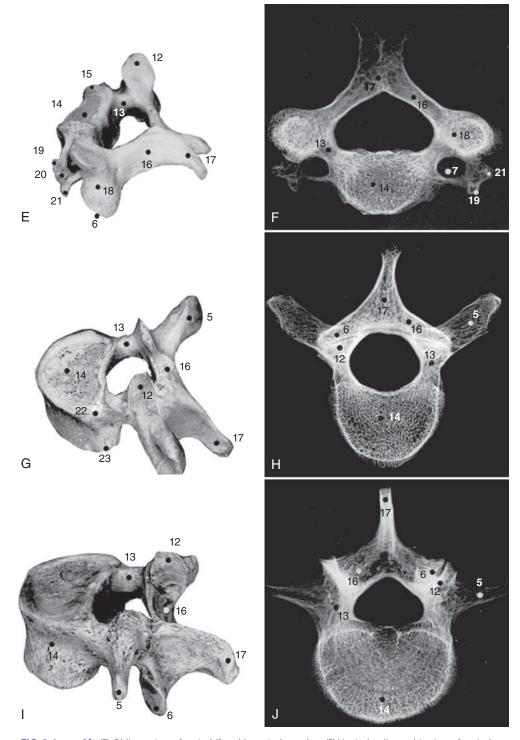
cont'd (E) Oblique view of typical (fourth) cervical vertebra. (F) Vertical radiographic view of typical cervical vertebra. (G) Oblique view of typical (fifth) thoracic vertebra. (H) Vertical radiographic view of thoracic vertebra. The plane of the articular facets would readily permit rotation. (I) Oblique view of typical (third) lumbar vertebra. (J) Vertical radiographic view of lumbar vertebra. The plane of the articular facets is situated to lock the lumbar vertebrae against rotation.
